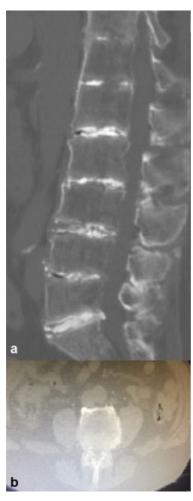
(a, b) Lumbar computed tomography showing calcifications of the lumbar vertebrae, especially L3, L4, and L5, with narrowed intervertebral disk spaces, intervertebral foramina, and vertebral canal.
